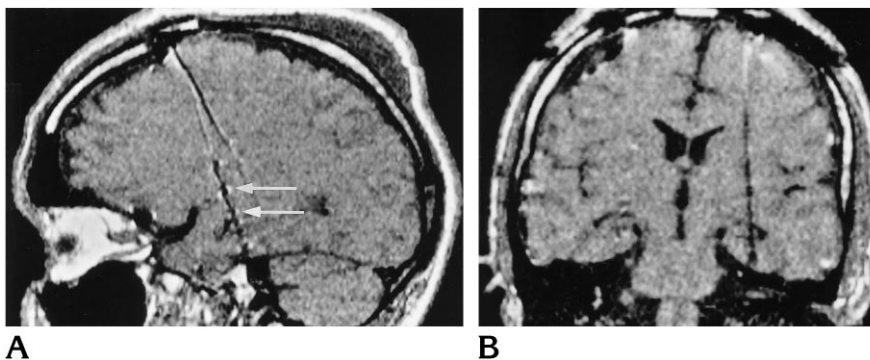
A, Sagittal reformatted fast spin-echo MR image (550/13), section thickness of 1.2 mm with left-to-right phase-encoding gradient, shows the separate contact points (arrows).
